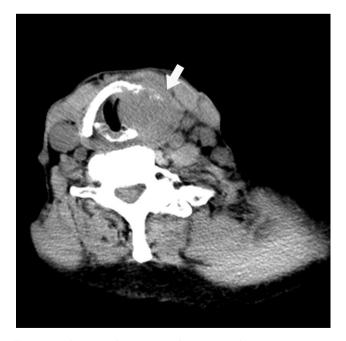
Computed tomography scan demonstrating an advanced hypopharyngeal tumor (arrow) invading the left lamina of the thyroid cartilage and compressing the airway.
